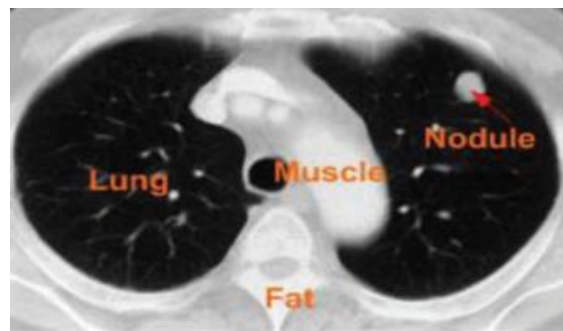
CT scans image of the patient with lung cancer.
